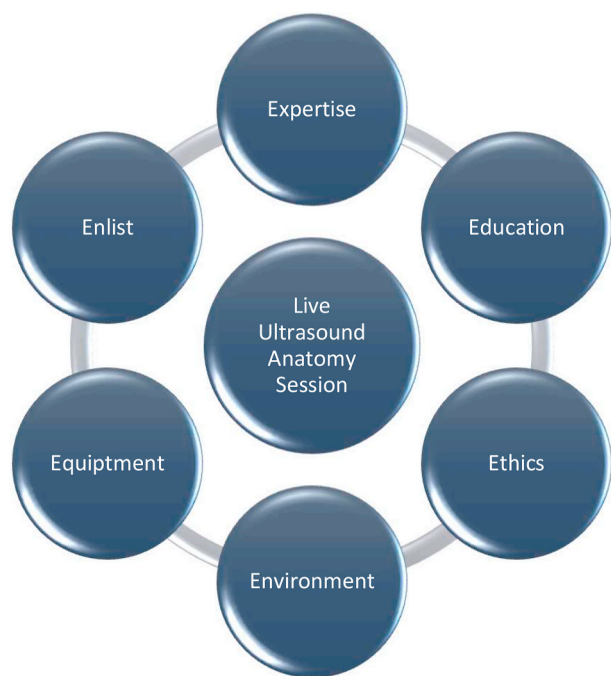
Outline requirements for the live ultrasound teaching sessions during anatomy teaching of year 2 medical students at the University of Bristol.
